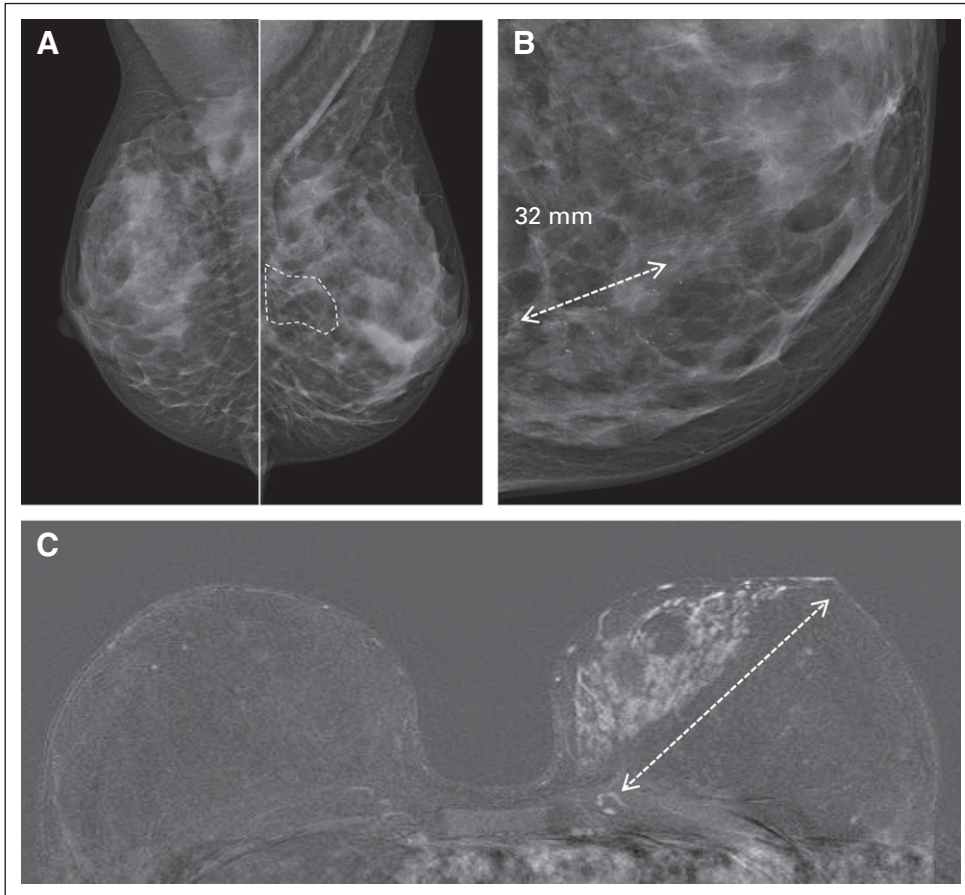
Depicting extent of pure ductal carcinoma in situ (DCIS). A 52-year-old patient had screening-detected calcification-associated DCIS in the posterior part of upper inner quadrant on mammography. Size on mammography was 32 mm in longest diameter. High-resolution ultrasound (12.5 MHz probe; not shown) was negative. Vacuum-assisted biopsy revealed high-grade DCIS. Magnetic resonance imaging (MRI) depicted the large DCIS that affected the entire upper inner quadrant and involved the nipple. Size on MRI was 82 mm. The patient underwent mastectomy that confirmed nipple involvement. Pathologic assessment of the size of the DCIS was 65 mm. Formal analysis would thus indicate MRI had overestimated the size of the DCIS. More likely is that pathology underestimated the size.
